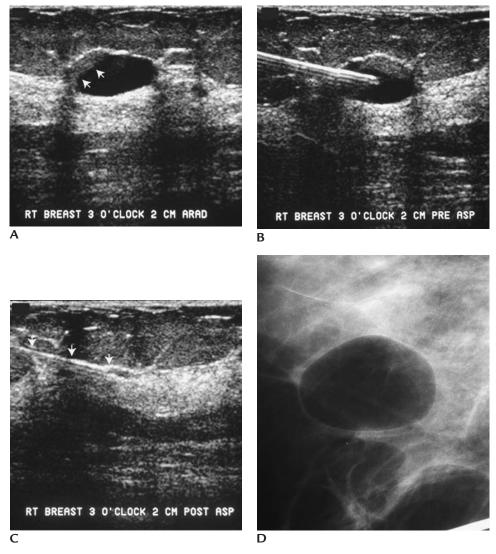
(A) Complex cyst. Because of the presence of echoes along a portion of the cyst wall (*arrows*), a mural lesion is a consideration and as such an ultrasound-guided aspiration with pneumocystography is undertaken for further evaluation. (B) Positioning of the needle in the center of the cyst. While observing under real time, fluid is aspirated. (C) Postaspiration image demonstrates needle (*arrows*) with no residual abnormality. Needle is stabilized and half of the aspirated volume of fluid is replaced with air. (D) Spot compression magnification view demonstrates smooth cyst wall. No mural lesion is identified on the pneumocystogram.
